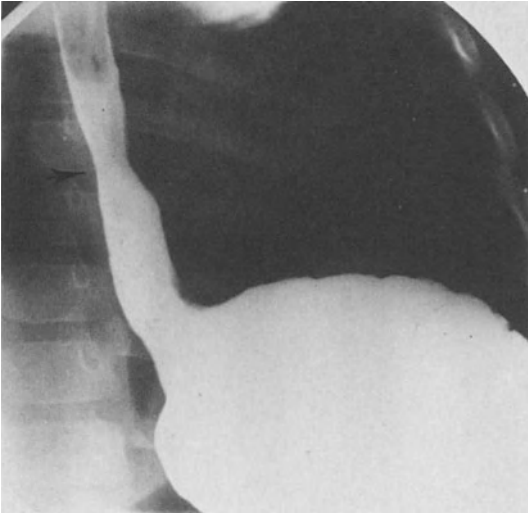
Sliding hiatus hernia, tubular type. Roentgenologic LES (*arrow*) is located above the hiatus
